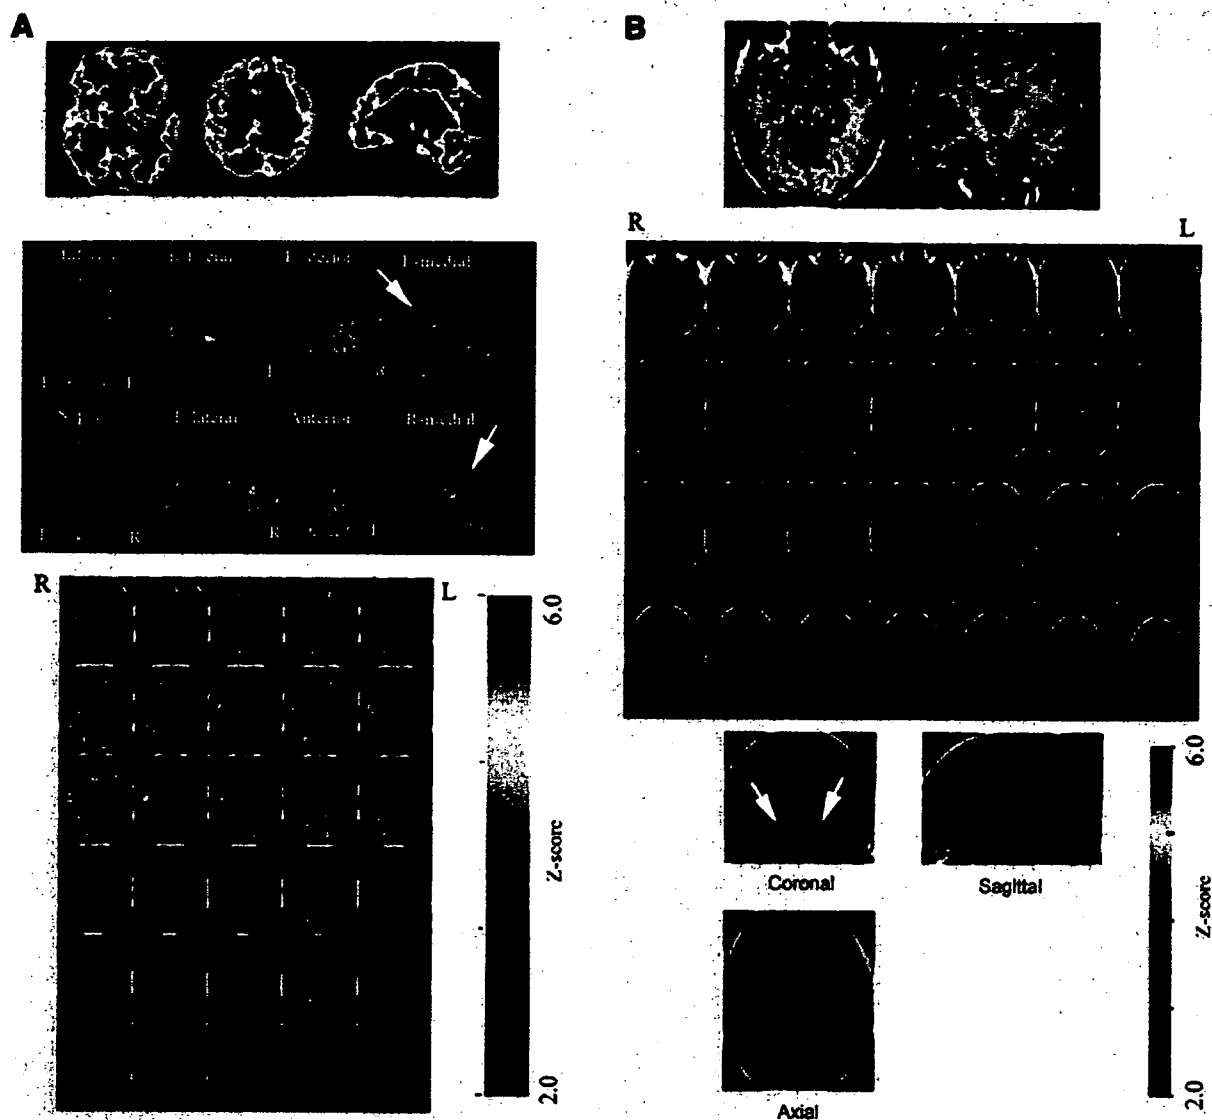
Statistical image analysis for 78-y-old woman with amnesic MCI. (A) Brain perfusion SPECT data were analyzed with z score mapping system. Specific VOI for very early AD (bilateral posterior cingulate gyri and precunei and parietal association cortex) is demarcated by red lines on MRI template. Significantly decreased rCBF above z score of 2 was observed within this specific VOI (arrows). (B) Gray matter images extracted from MR images were analyzed with z score mapping system. Specific VOI for very early AD (bilateral medial temporal areas, including parahippocampal gyri and amygdaloid bodies) is demarcated by pink sections on MRI template. Significantly decreased gray matter concentration above z score of 2 was observed within this specific VOI (arrows).
